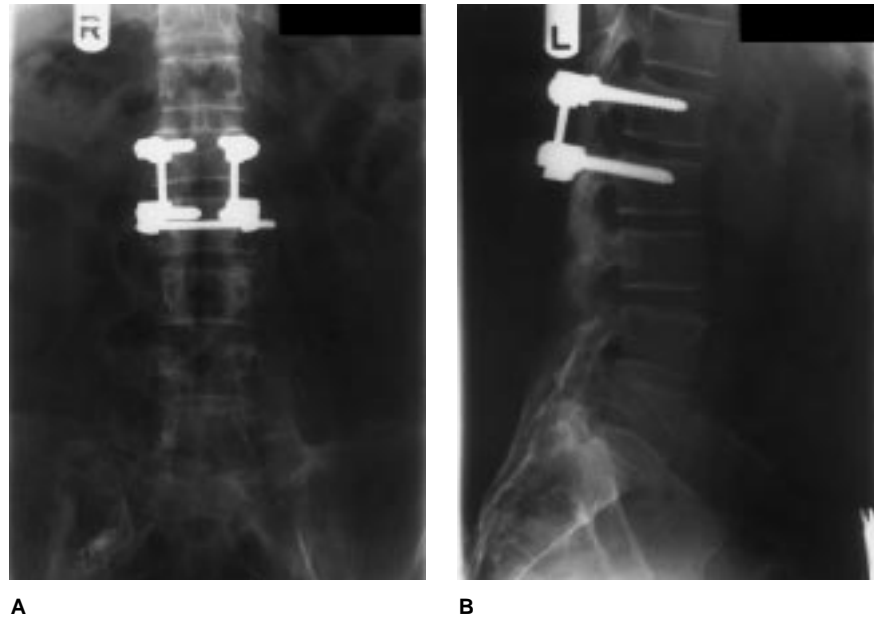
Attempted posterolateral fusion with internal fixation at L1-L2 resulted in atrophic pseudarthrosis. Anteroposterior (A) and lateral (B) radiographs depict solid fusion between L4 and S1.
